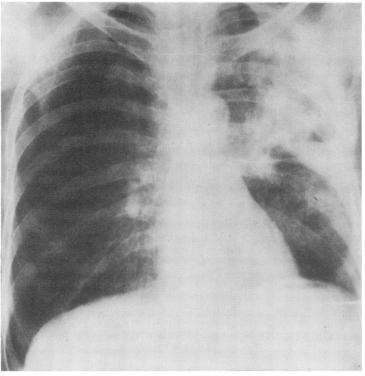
Case 7. Chest radiograph at start of illness showing consolidation and cavitation in left upper lobe.
